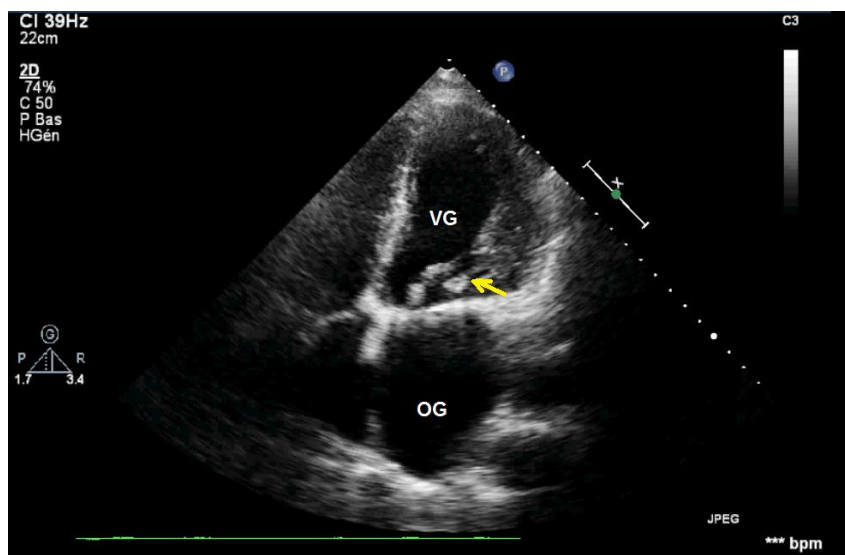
Trans-thoracic echocardiography showing abscess in the vicinity of the mitral annulus
